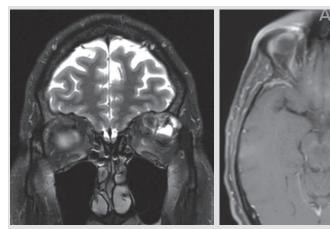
Outside imaging center MRI images with left orbital mass, read as, "lobulated with enhancement of septations. A small vascular channel is seen ... The most common lesion of this nature in this area is a slow-flow venous malformation. Other vascular lesions are not excluded."
